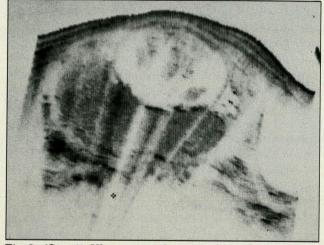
(Case 1). Ultrasonography at 36 weeks' gestation reveals fetal ascites.
